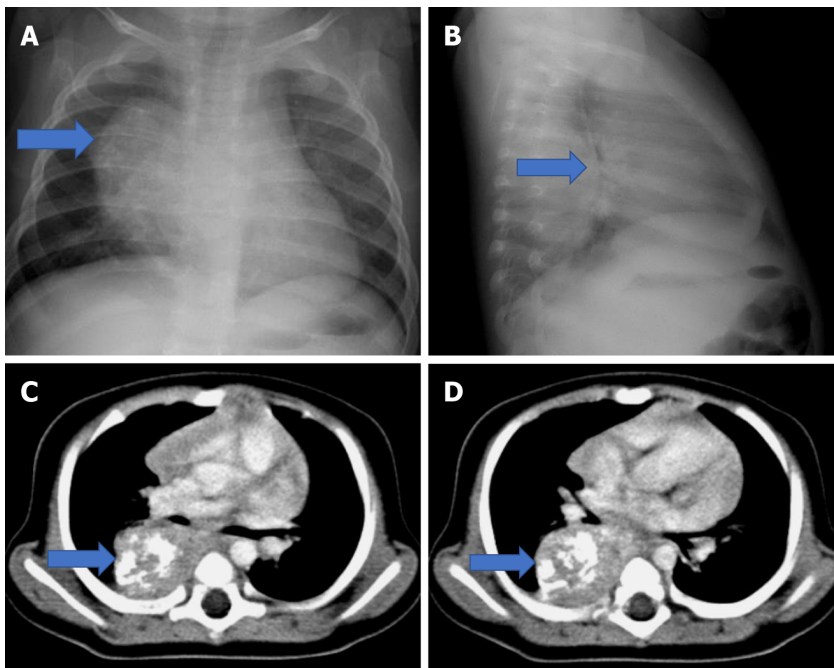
A 6 mo old male patient. A: On posteroanterior chest radiograph right paravertebral; B: Lateral radiograph posteriorly located smooth-contoured density (blue arrow) is observed; C: Esophageal duplication cyst (blue arrow). In the axial computed tomography images of the same patient, a lobulated contoured cyst is observed in the middle mediastinum, adjacent to the esophagus, and it extends into the posterior mediastinum.
